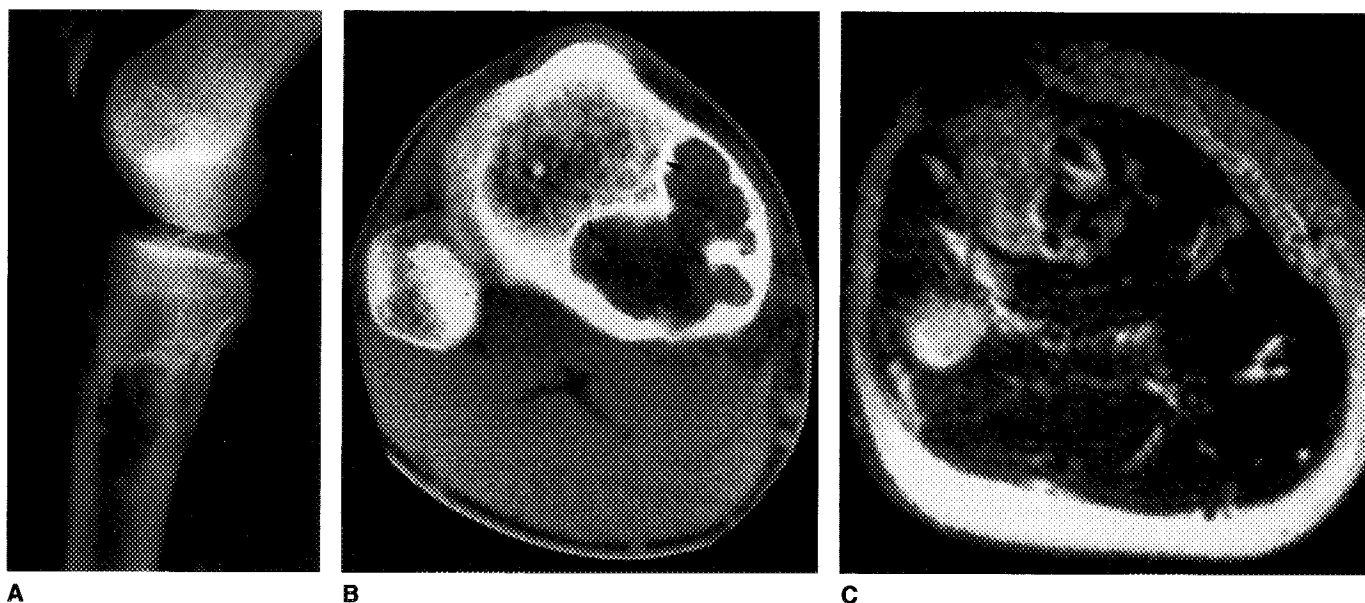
Incidental fibroxanthoma detected within the left tibia of a 14-year-old male. Lateral knee radiograph (A) depicts a characteristic trabeculated lytic metadiaphyseal lesion abutting the proximal epiphyseal plate with the sclerotic margins. CT (B) and axial T2-weighted (2000/90) MR image (C) demonstrates an intracortical lobulated lesion with well-defined, intact, sclerotic margins. There is soft tissue attenuation on CT and sclerotic inner margin representing endosteum (arrowheads). The lesion is predominantly low signal on MR imaging due to high collagen content.
